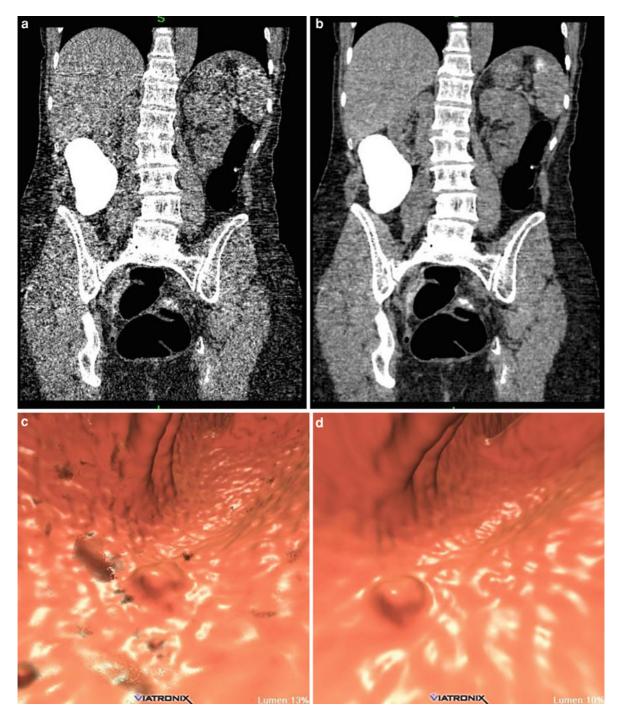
Comparison of image quality. a Coronal CT colonographic (CTC) two-dimensional image reconstructed with FBP. Note the importance of noise. b Coronal CTC two-dimensional image reconstructed with PICCS shows a significant decrease in noise. c Three-dimensional endoluminal ultra-low-dose CTC (effective dose: 0.3 mSv) reconstructed with FBP. Polyp is barely visible amongst the noise but is well seen on threedimensional endoluminal ultra-low-dose CTC reconstructed with PICCS d. Images are courtesy of Perry J. Pickhardt and Meghan G. Lubner, University of Wisconsin School of Medicine and Public Health, United States of America
